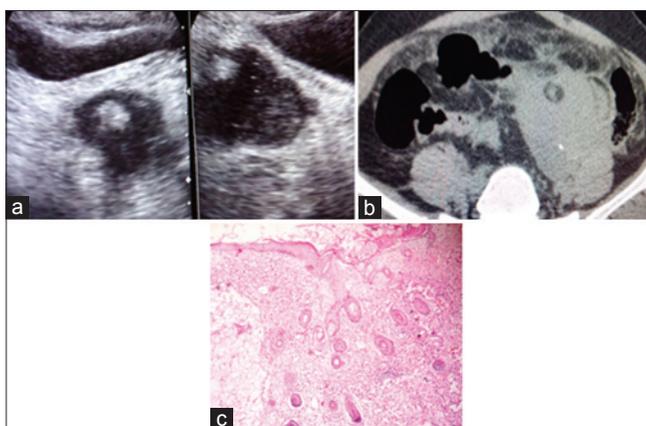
(a) Ultrasonography and (b) computed tomography scan showing ruptured dermoid cyst with omental inflammation, (c) microphotograph of dermoid shows cyst lined by stratified squamous epithelium with underlying adnexal structures
